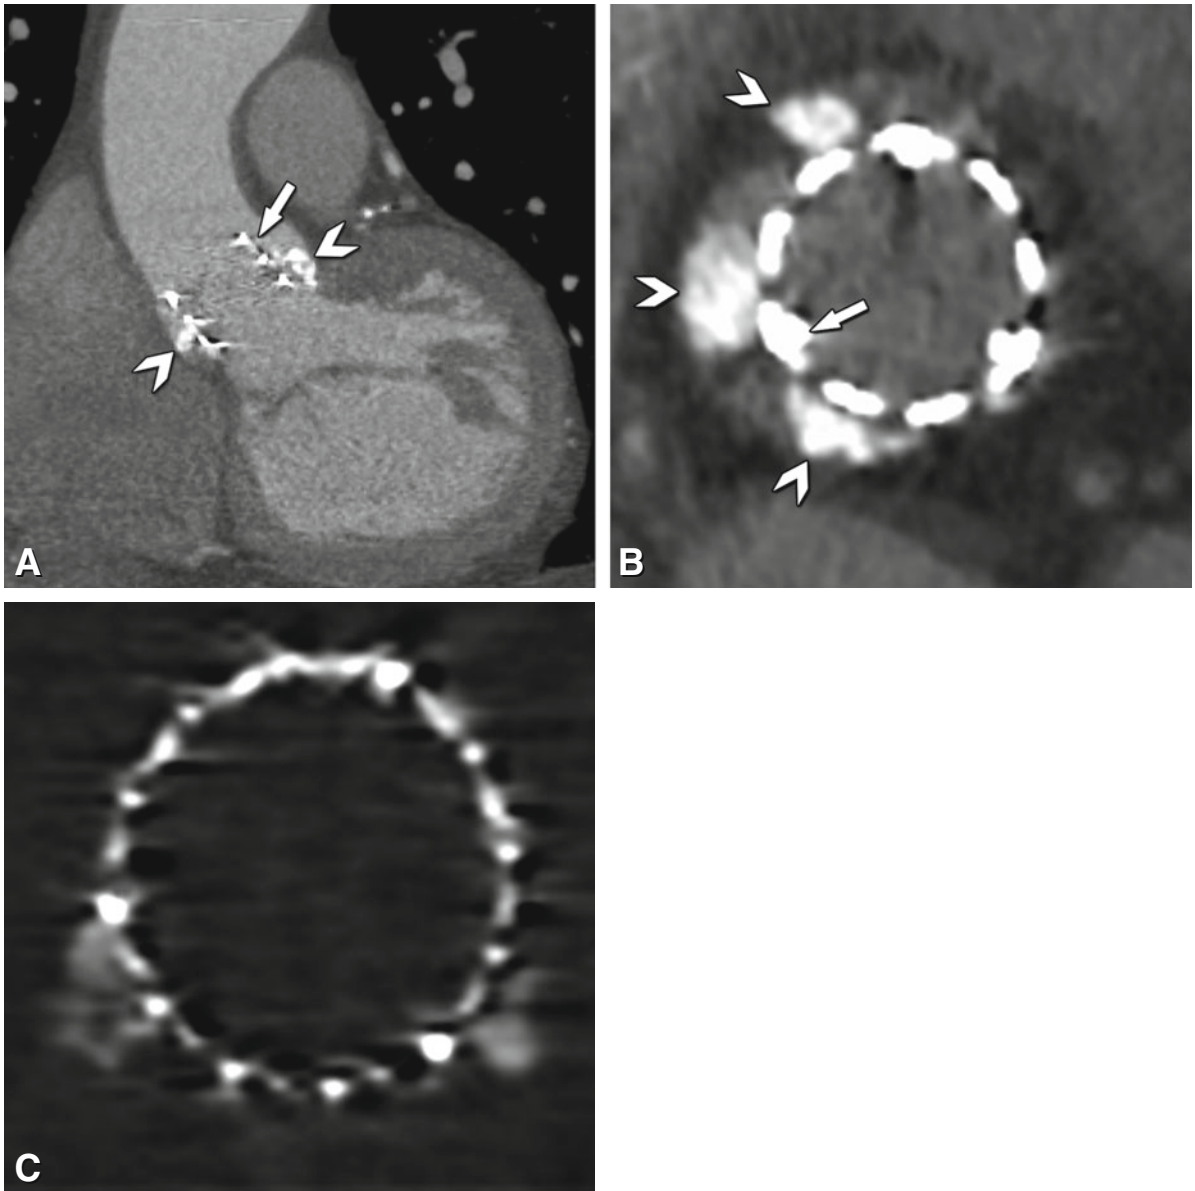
Two examples of CT done for assessing the quality of deployment of the aortic valve. The first patient has a heavily, asymmetrically calcified aortic annulus (*arrowheads*) with incomplete stent adaption (*arrow*, Panels A and B). Even though this did not result in significant intraprocedural paravalvular leakage, the patient developed grade II regurgitation after 2 years of follow-up. Panel C shows a 140 keV monochromatic view of a 29-mm Sapien device in another patient. To evaluate stent circularity (perfect in this case) and positioning of the prosthesis, the examination was performed without contrast agent injection. Dual-energy CT reduces blooming artifact and may improve the differentiation of stent from native calcifications
